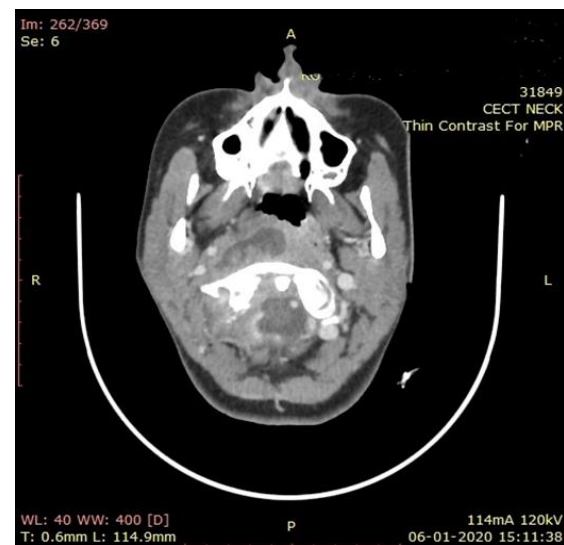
CT Scan Axial views showing irregularity of right atlanto-occipital joint and destruction of occipital condyle.
